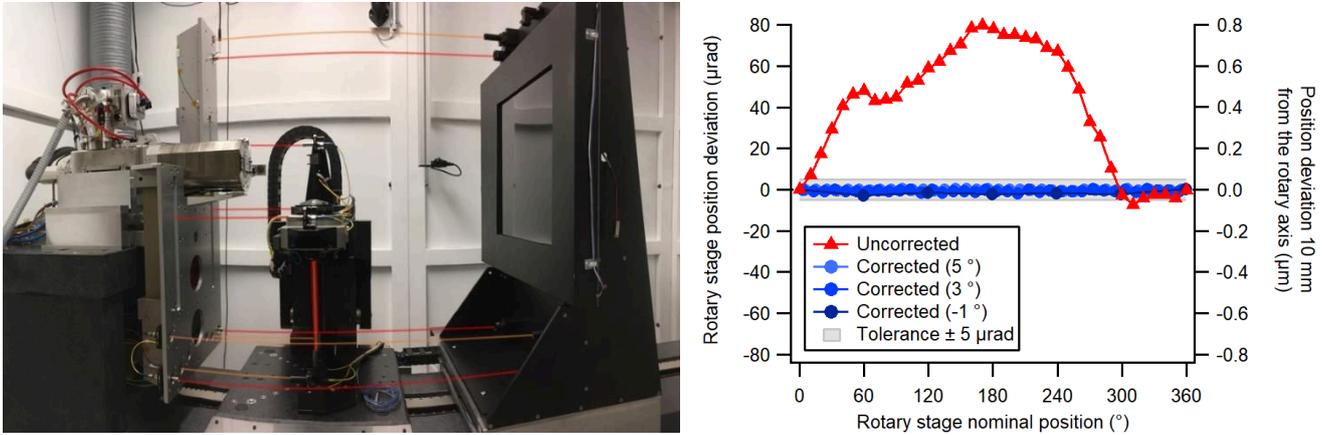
Left: Photograph of METAS-CT. The laser beams of the geometry measurement system are indicated in red (interferometers) and orange (straightness sensors). All measurements are made relative to the metrology frame on the left. Right: Positioning error of the rotary stage before (red triangles) and after correction (blue circles). The optical polygon was rotated by a fraction (5° , 3° , -1°) of its angular step (10°), to evaluate the interpolation accuracy of the correction.
